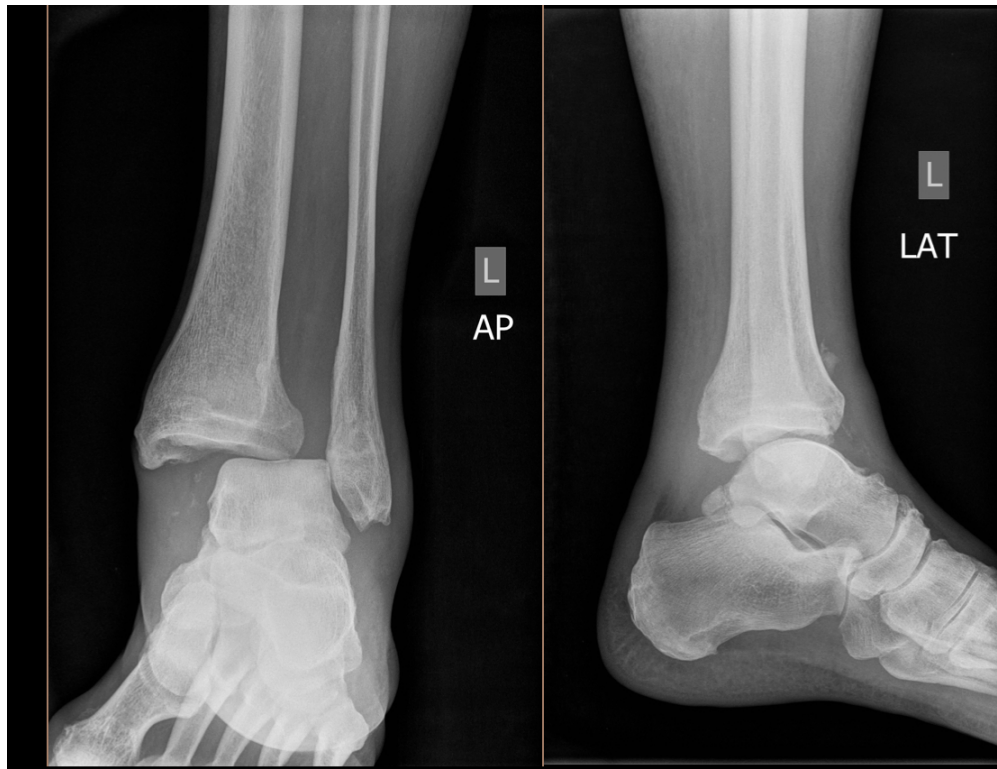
AP and lateral radiographs of the left ankle demonstrating dislocation of the tibiotalar joint with anterolateral displacement of the talus and medial clear space widening.
